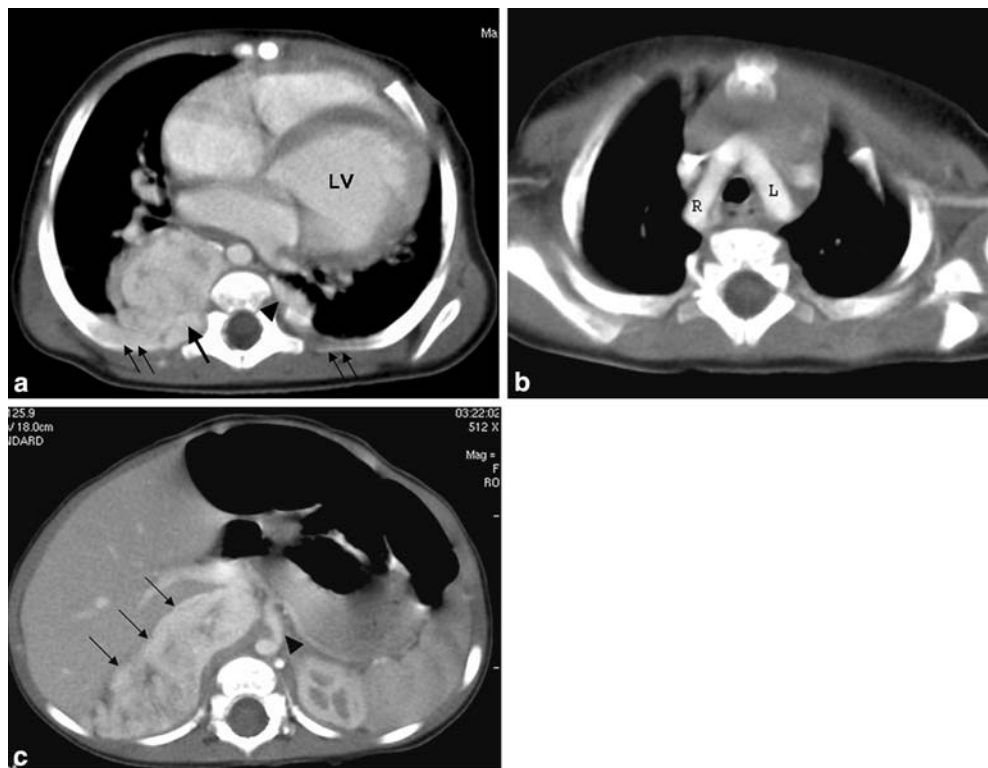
Contrast-enhanced CT of the chest demonstrates an enhancing mass (*double arrows*) in the posterior right paraspinal region. There is a right aortic arch (*R*) with an aberrant left subclavian artery (*single arrow*)
